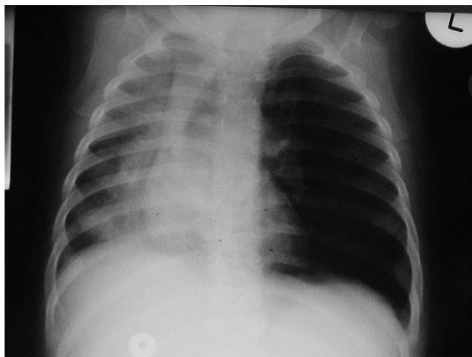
Chest radiograph of a child with a ball-valve effect (left-sided hyperinflation) caused by lymph node compression of the left main bronchus.
